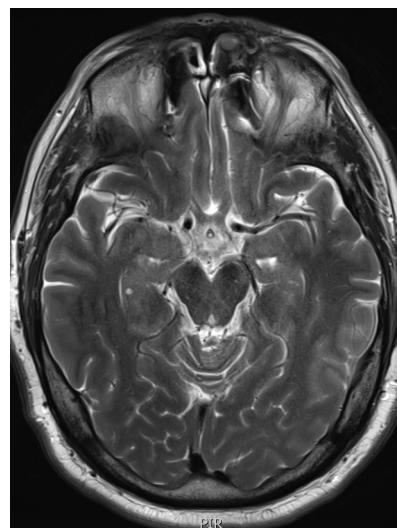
MRI head. Another axial view of his MRI head.
